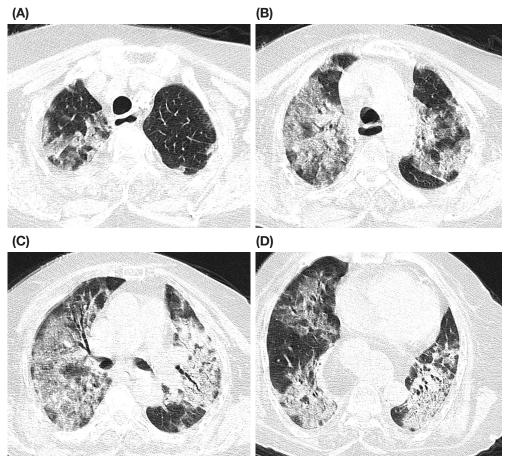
A 71-year-old, diabetic woman without heart failure, hospitalized with severe disease at presentation, shows extensive lung parenchymal involvement, mainly GGO with minimal consolidation in her first-day in-hospital CT scan (A-D): CTSS1=17/24, CTSS2= 33/48, CTSS3= 13/20, CTSS4= 18/25, CTSS5=21/30, CTSS6= 18/20, CTSS7= 33/40. She was admitted to ICU (severe disease at triage), got intubated after 2 days (critical disease) and died after 6 more days (critical outcome).
